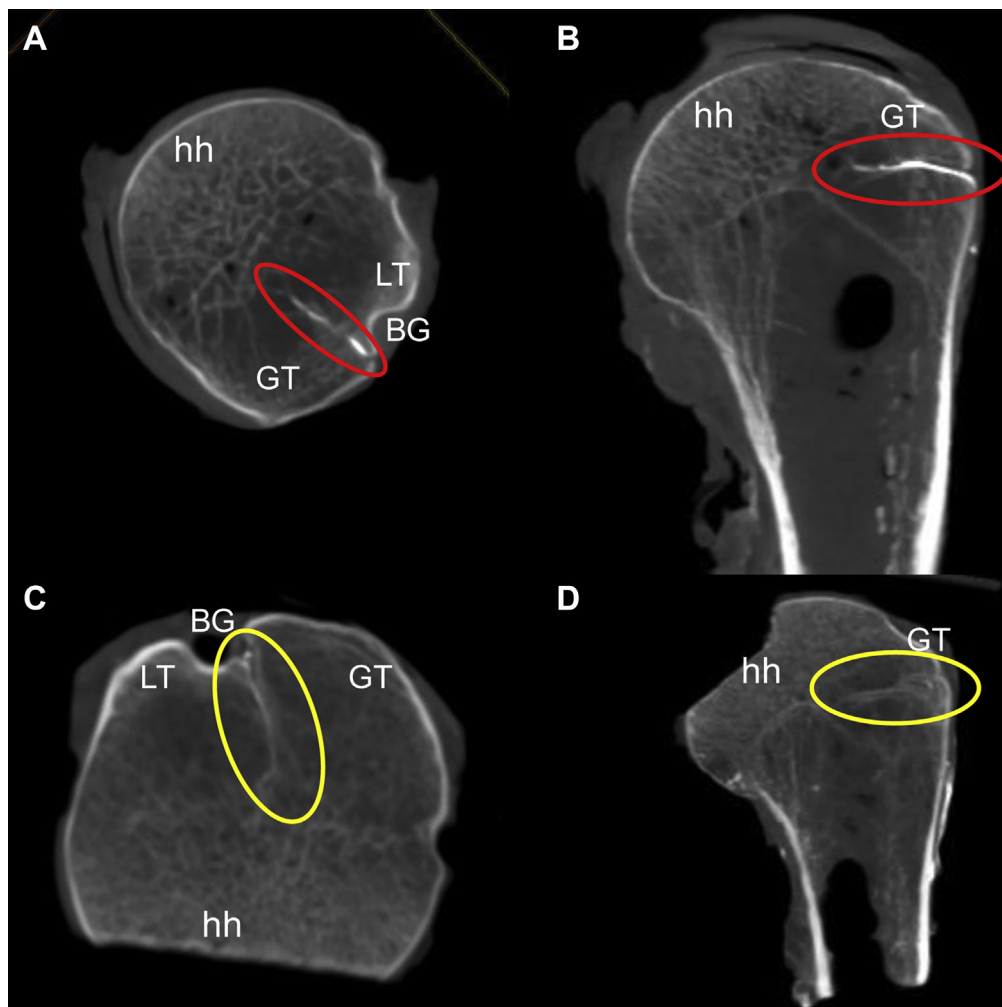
(A and B) Axial and coronal microfocus-CT views of the proximal humerus of individual 1, clearly showing the arcuate artery's (red oval) entrance into the superolateral aspect of the bicipital groove (BG) and its intraosseous course into the greater tuberosity (GT) with its medially migration toward the humeral head (hh); (C and D) Axial and coronal microfocus-CT views of the proximal humerus of individual 2, clearly showing the arcuate artery's (yellow oval) entrance into the superolateral aspect of the BG and its intraosseous course into the GT with its medial migration toward the hh. CT, computed tomography; LT, lesser tubercle.
